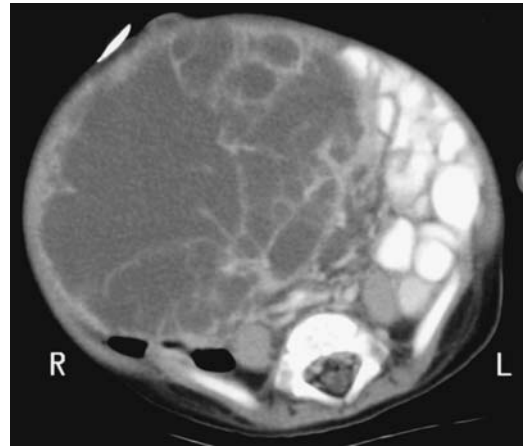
Liver mesenchymal hamartoma in an 8-month-old boy. Computed tomography shows a complex, mostly cystic tumor replacing most of an enlarged liver. Mild contrast-enhancement was evident in the solid component. (Courtesy of Luann Teschmacher, M.D., University of Rochester.)
